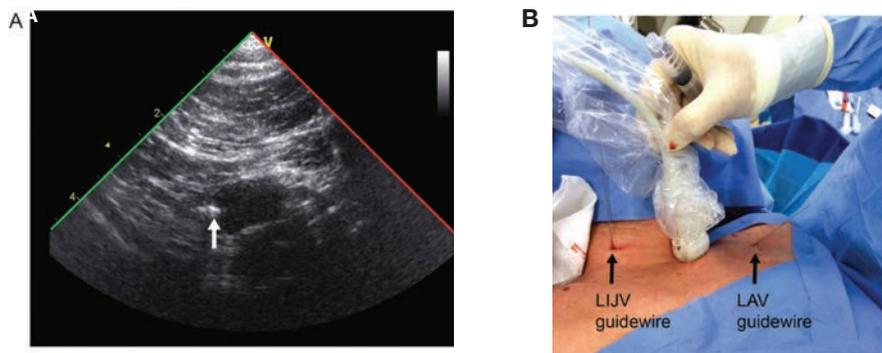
Axillary vein guidewire. (A) Guidewire coming from the left axillary vein (LAV) (arrow) (B) In order to see the guidewire the ultrasound probe can be positioned above the LAV or along the left internal jugular vein (LIJV) just above the left clavicle. (With permission of Denault et al. *Basic Transesophageal and Critical Care Ultrasound 1st Edition*, CRC Press Taylor & Francis Group 2016.)
